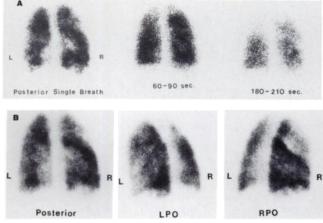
A 50-yr-old male referred for V/Q scan to rule out pulmonary emboli because of increasing shortness of breath. Chest x-ray showed no infiltrates. The ventilation study (A) reveals obstructive airway disease involving more than 50% of combined lung fields as seen particularly on the washout image of 180–210 sec. The single-breath image reveals multiple focal areas of decreased to absent ventilation in both lungs that match the areas of decreased to absent perfusion seen mainly on posterior view (B). Note that determining this matching pattern using washout images is difficult. Pulmonary angiography performed the same day was negative for pulmonary emboli.
